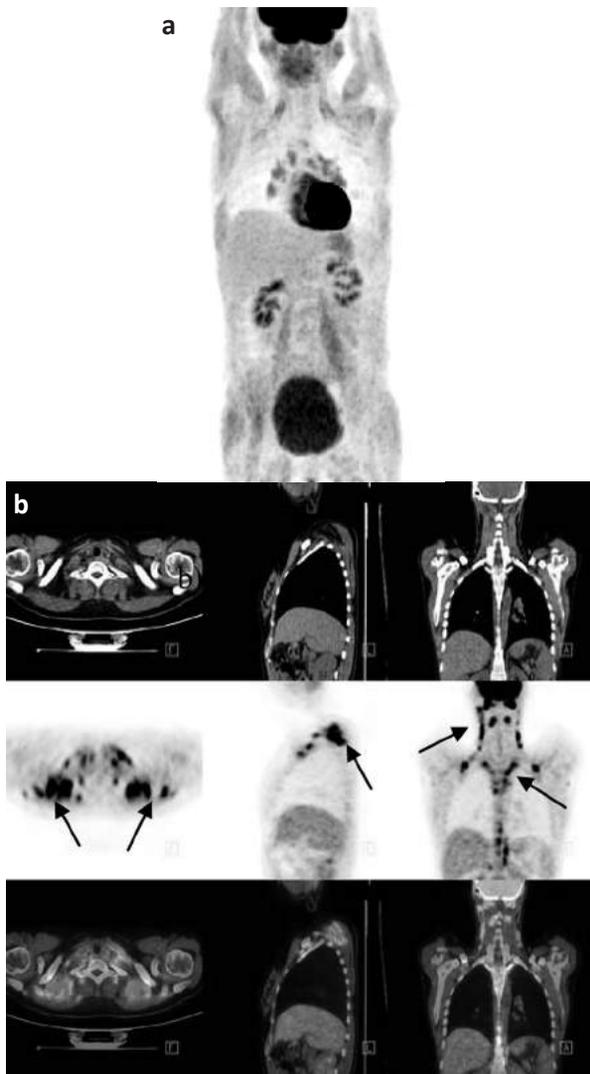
a) Maximum Intensity Projection (MIP) image shows intense ^{18}F -FDG uptake in muscles of patient who did not fast prior to examination; b) Physiological ^{18}F -FDG uptake in brown adipose tissue in 20-year old female; (rows, from top to bottom in transversal, sagittal and coronal planes: CT images, PET images, fused PET/CT images)
